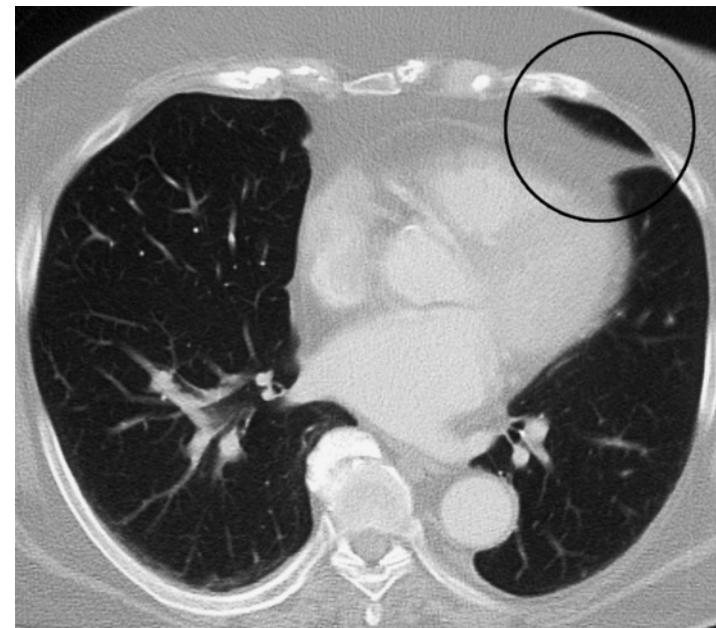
CT image (detail enlargement) of a pleuropericardial callus. Narrow projection of pericardial fatty tissue with normal adjacent lung tissue.
